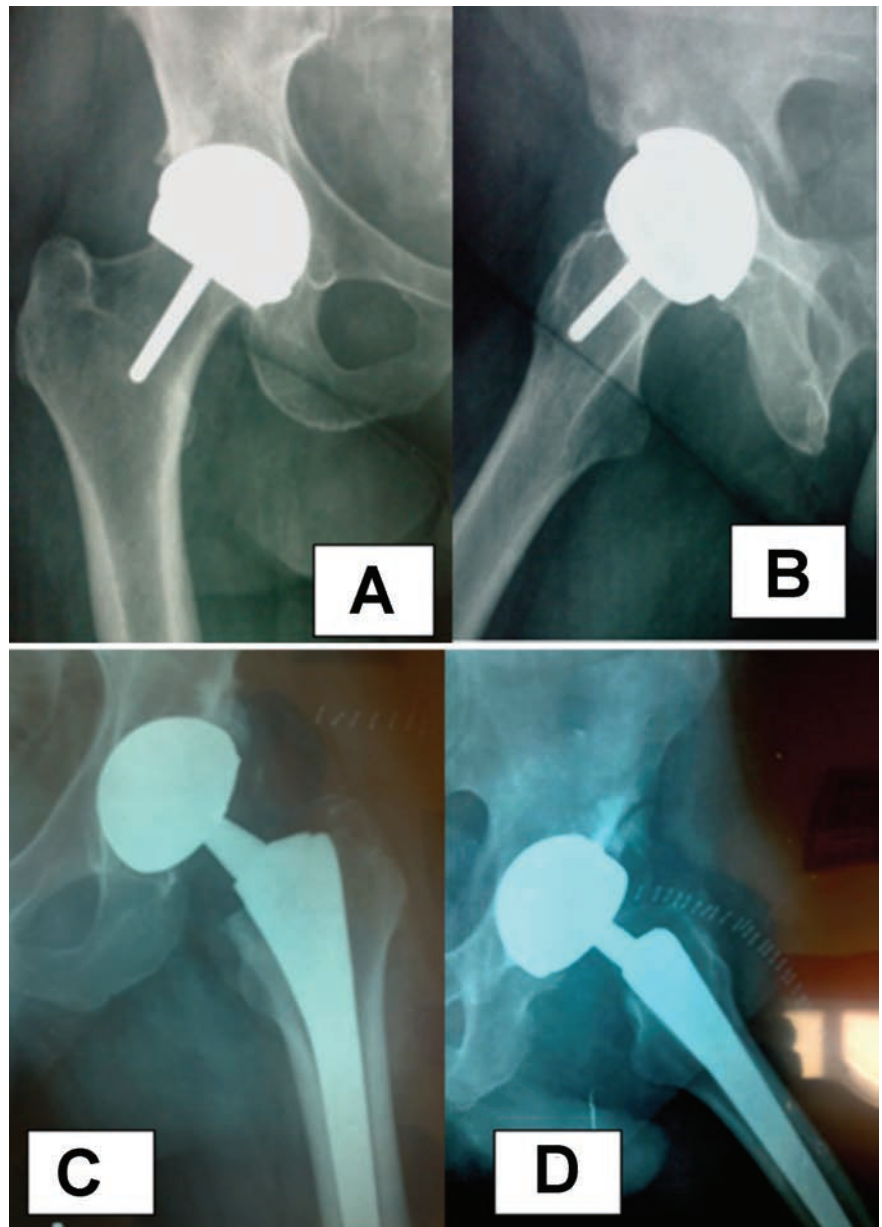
A,B) Anteroposterior and lateral hip x-rays of a patient submitted to total hip resurfacing replacement; C, D) anteroposterior and lateral hip x-rays of a patient submitted to big femoral head-total hip replacement.
